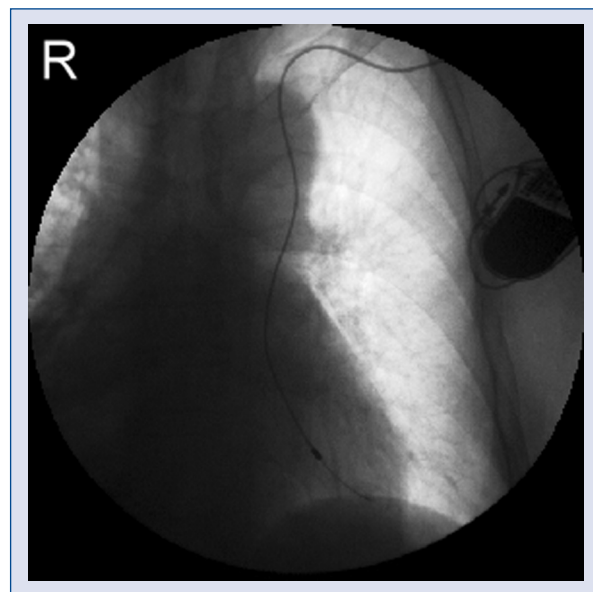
Postero-anterior chest radiograph demonstrates the ventricular lead in a postero-lateral cardiac vein (Case 3).
